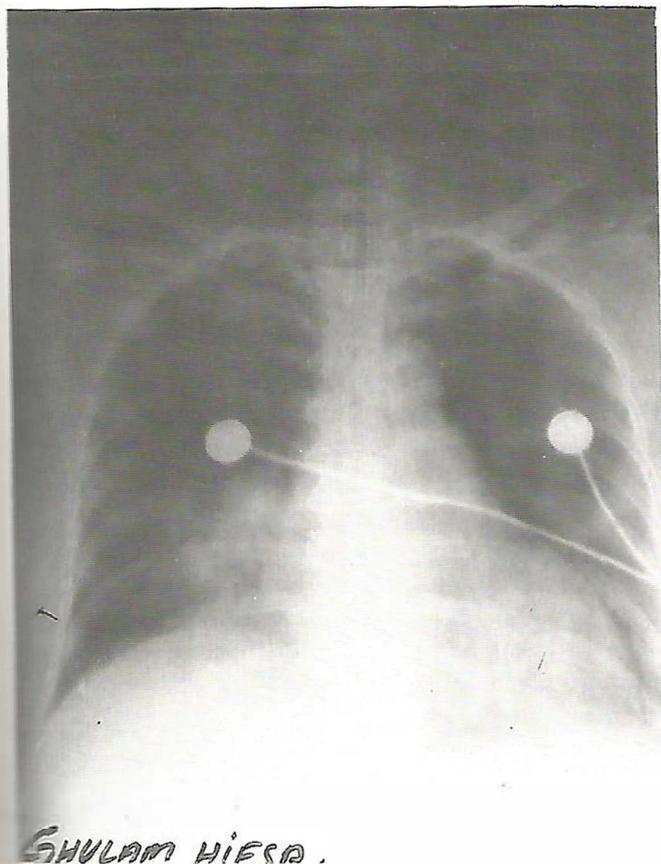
4. Post operative X-Ray chest showing raised of right hemidiaphragm and mild pleural effusion.
